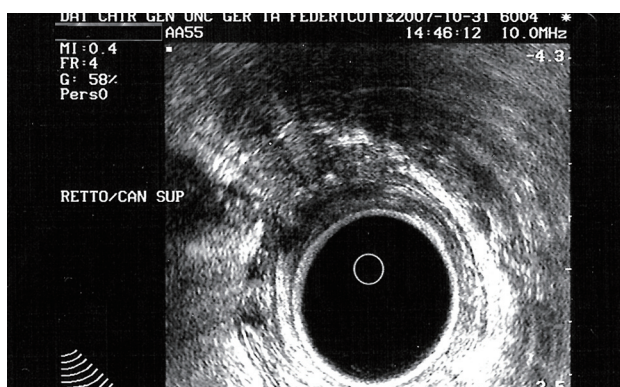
Endoanal ultrasound scan showing a mass located in the anterior wall of the rectum.
